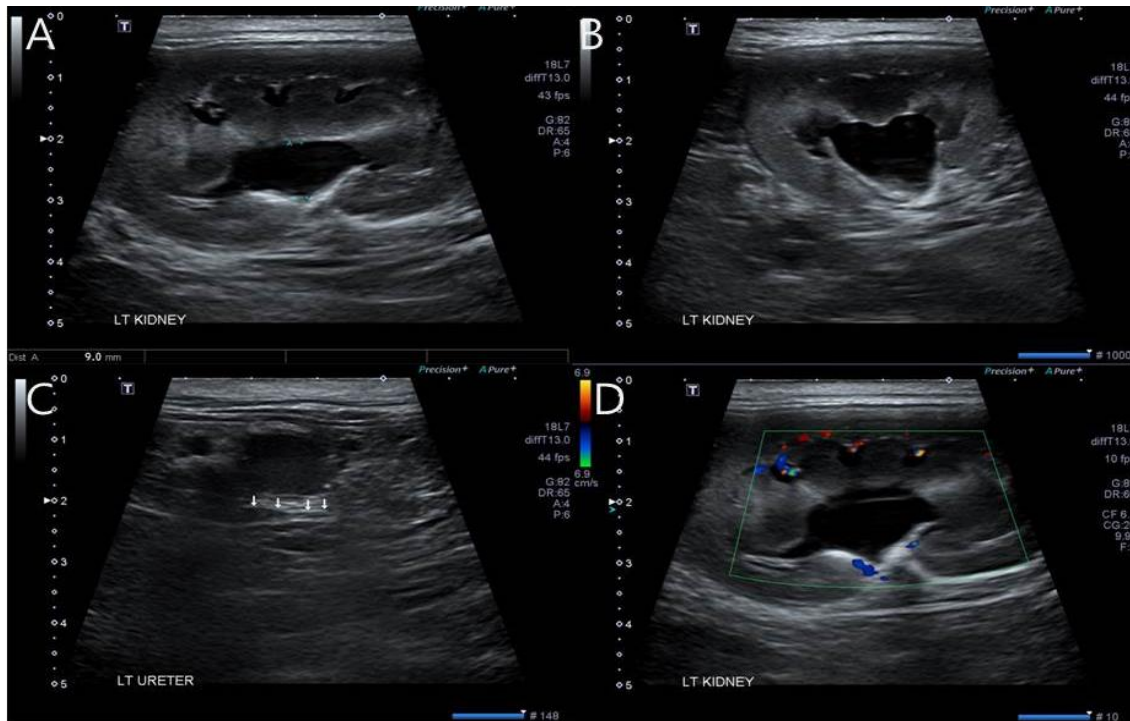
Ultrasonography images of affected left kidney. (A-B) The diameter of left renal pelvis was extended 9 - 13 mm. (C) The site of stenosis in the proximal urethra was identified. (D) For the evaluation of the renal function, a RI value was measured in the arcuate artery, which was found to be as high as 0.72 (D).
